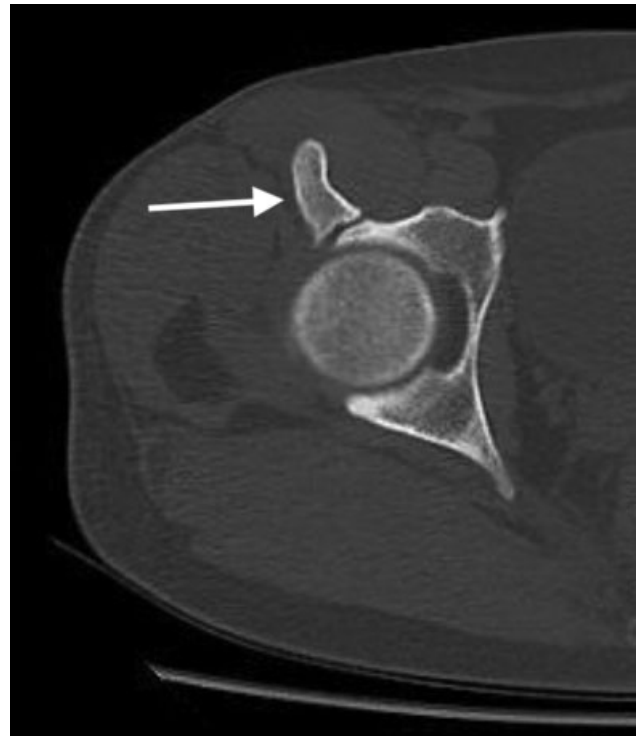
Preoperative image of computed tomography in axial section, showing the presence of prominent anterior inferior iliac spine (white arrow).
